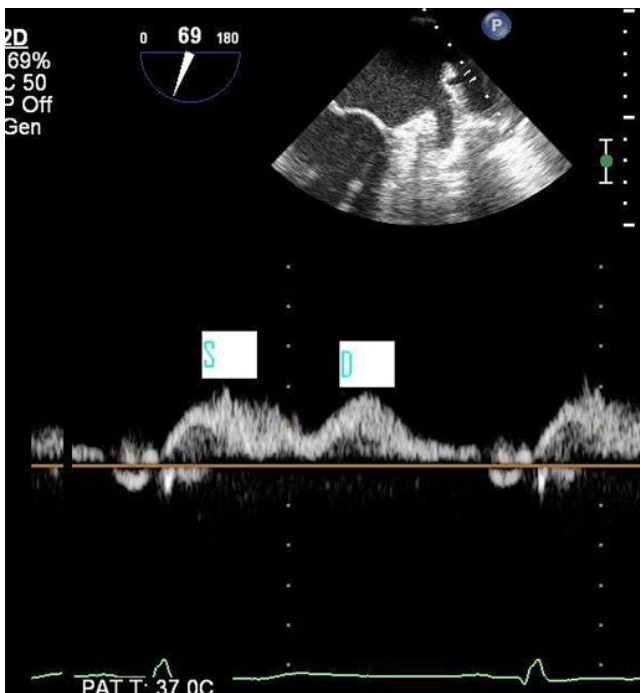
TOE pulsed-wave Doppler tracing of the left upper pulmonary vein showing systolic (S) and diastolic (D) flow. The velocity scale is not shown, but would ideally be lowered to give greater velocity resolution.
